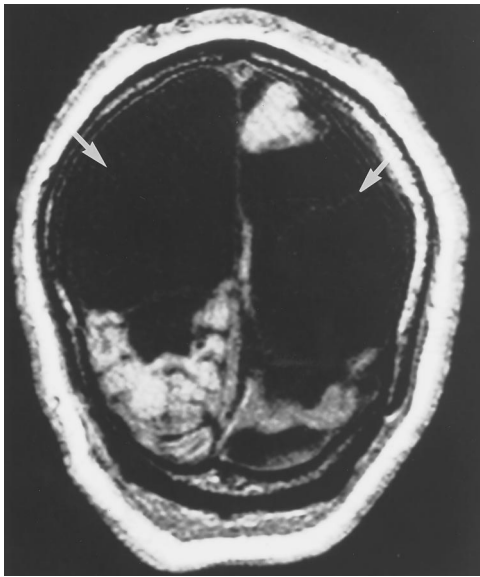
Case 14: patient with complex partial seizures and bitemporal interictal discharges on EEG. Volumetric T1-weighted MR image (20/6.2/1) in the coronal plane shows bilateral porencephalic cysts (arrows) in the posterior cerebral artery distribution.
